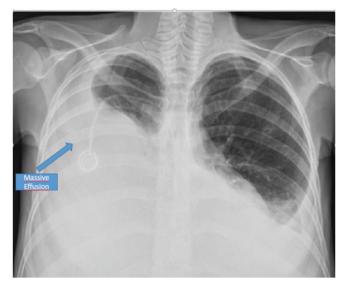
X-ray massive PE compromising the right pleural cavity PE: Pleural effusion
